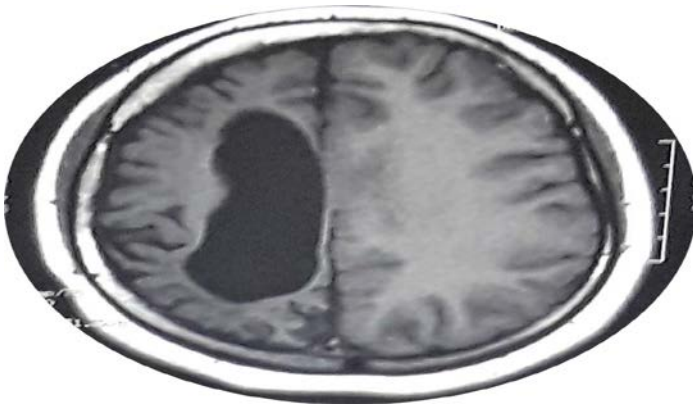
MRI of the patient revealed unilateral cerebral hemi-atrophy.
